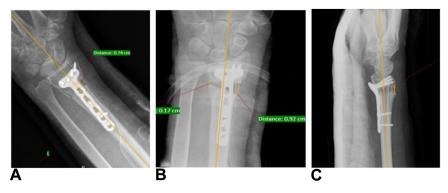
A The osteotomy defect (mm) length is measured on the postoperative radiograph. B A larger osteotomy length is considered for final evaluation in the case of oblique gap osteotomy. C The osteotomy length at the noncontact cortex was measured and considered for final evaluation.
